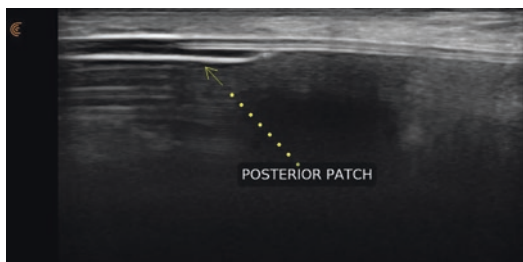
Grayscale ultrasound image of the posterior patch of a silicone gel breast implant
